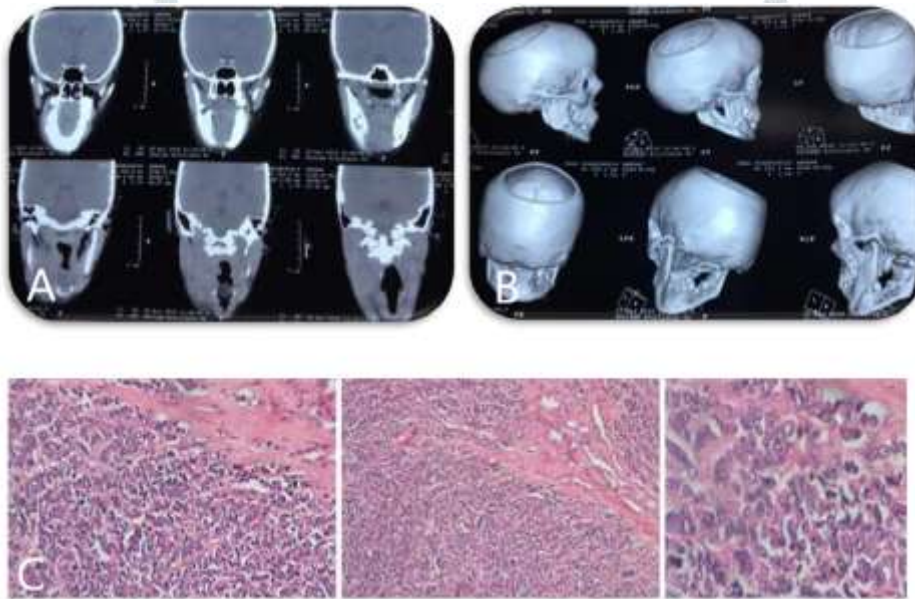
A, B- CT Scan, C- HPE examination
